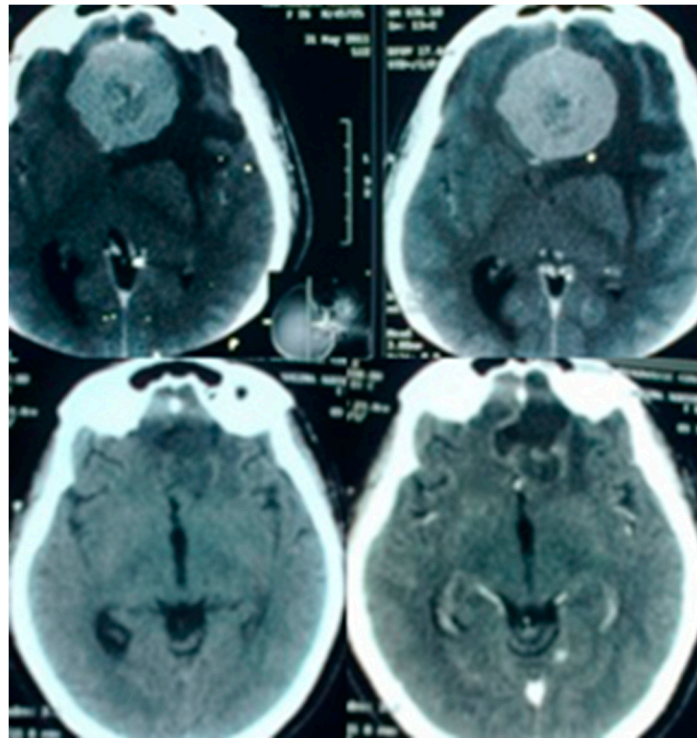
Contrast CT scan of brain axial sections; upper row shows preoperative olfactory groove meningioma, and lower row shows postoperative complete excision of meningioma. Source: Figure by authors.
